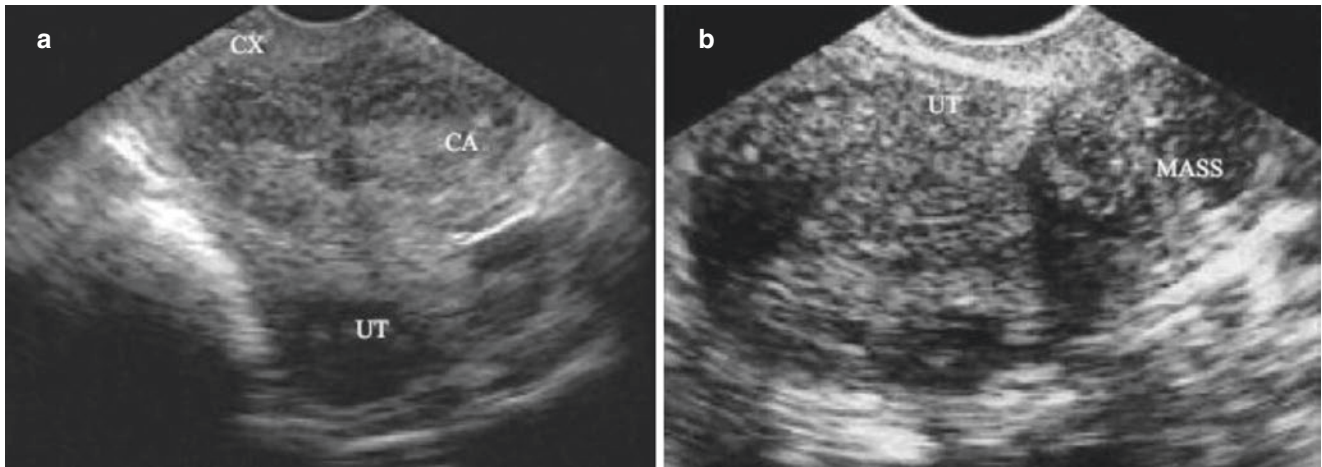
The differentiation of cervical cancer and cervical myoma. (a) A cervical cancer patient. Sonogram shows the larger cervical diameter compared with the corpus, abnormal cervical morphology, and irregular and heterogeneous mass. (b) Cervical leiomyoma, which is
